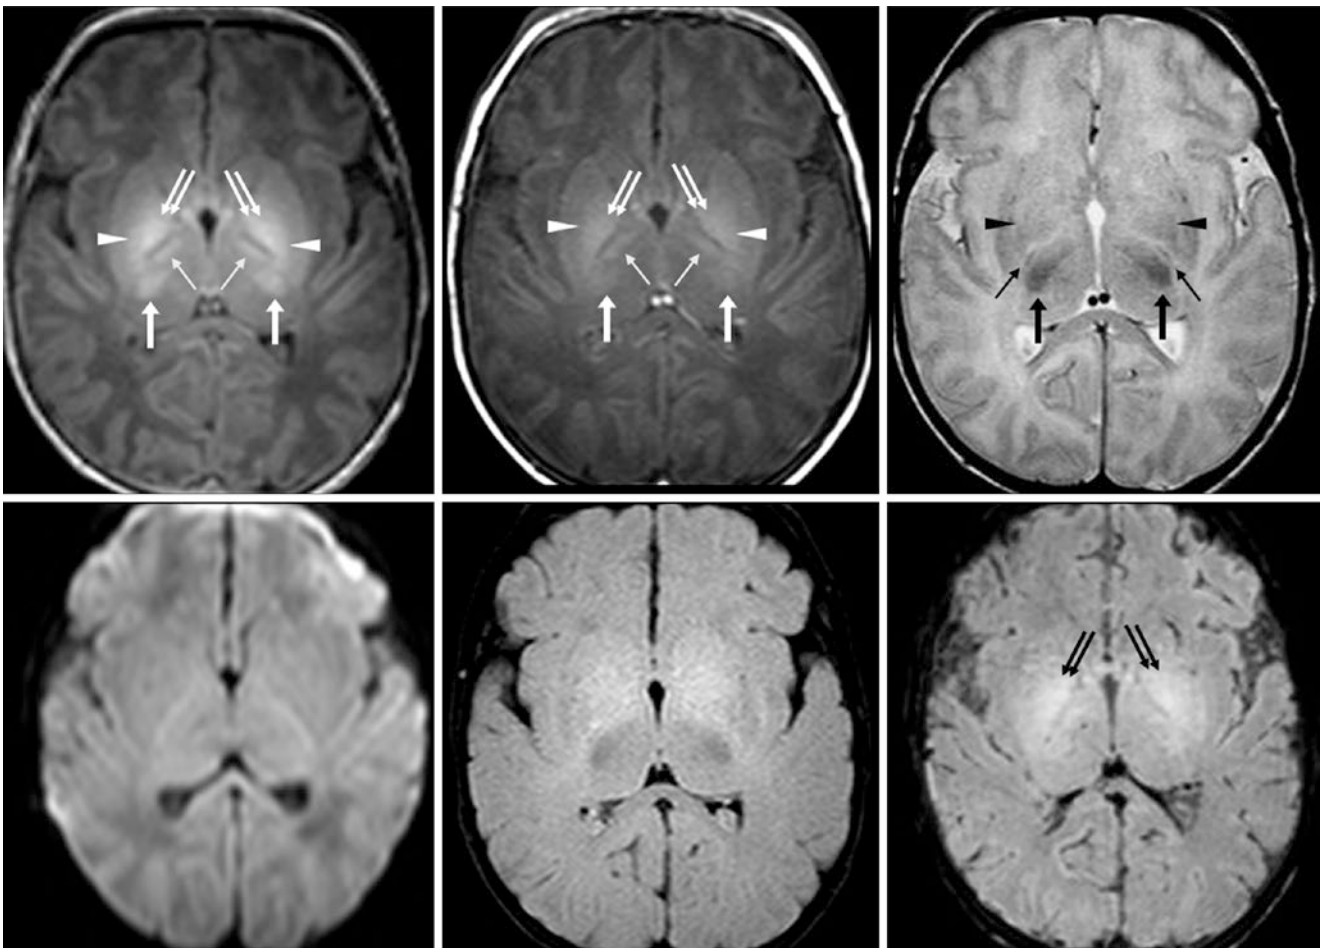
A 4-day-old term neonate with a hypoxic event had a normal 3T MRI, which included spoiled GE T1WI (*top left*), SE T1WI (*top middle*), SE T2WI (*top right*), DWI (*bottom left*), FLAIR (*bottom middle*), and SWI (*bottom right*). Note that the LN are brighter on GE
